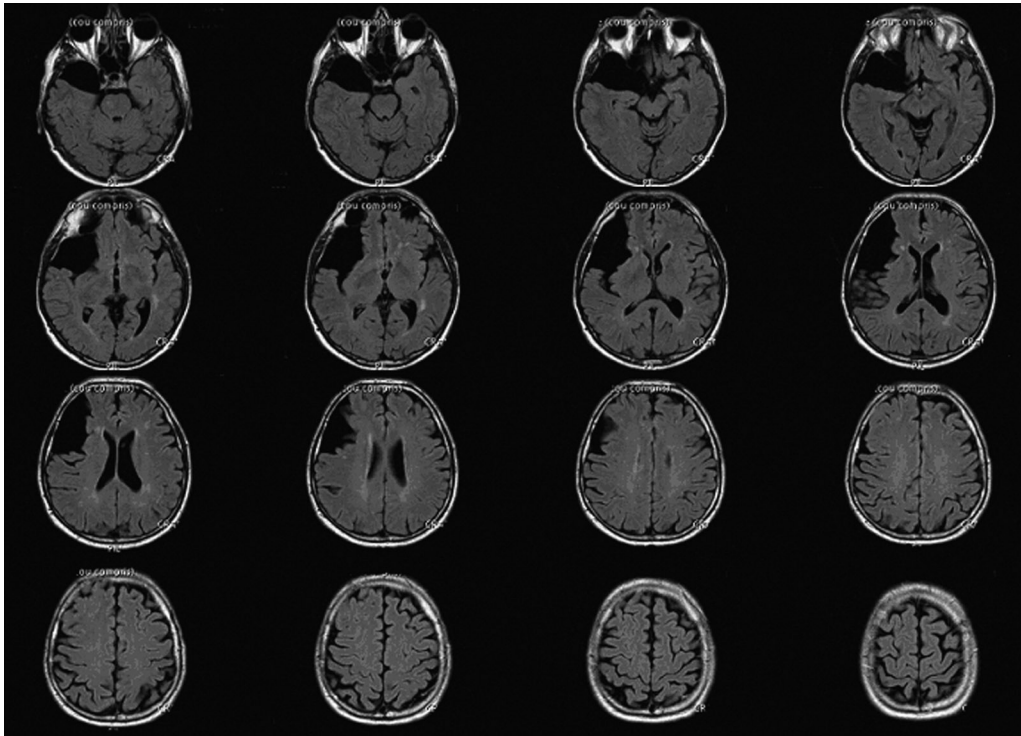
Structural MRI showing an arachnoid cyst of the right anterior temporal and the right lateral prefrontal cortex (dimension, 7.6×4.1 cm in the axial plane and 8.1 cm in the coronal axis).
